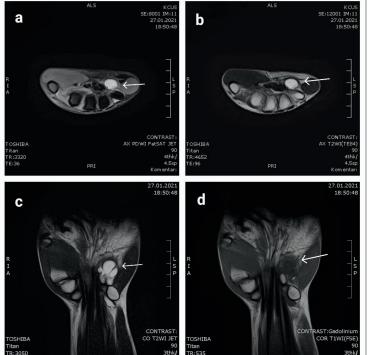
MRI scans of the left hand's Guyon's canal reveal a well contained thinwalled cystic lesion with somewhat lobulated outlines and a homogenous hyperintense signal on T2WI sequence. It is in hyposignal on the T1 postcontrast sequence with no evidence of signal intensity amplification, which is consistent with a benign ganglion
